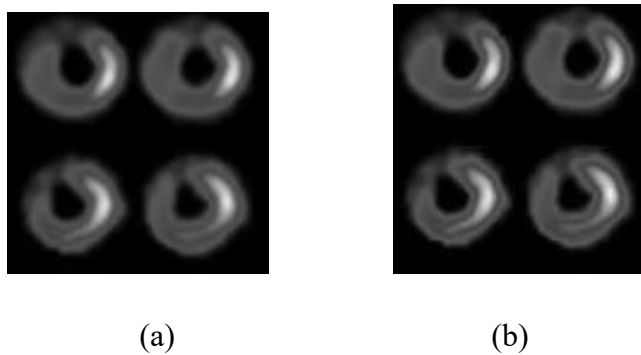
(a) Cardiac SPECT image blurred using a Gaussian PSF with $\sigma=5$ and (b) Deblurred image using the proposed method
